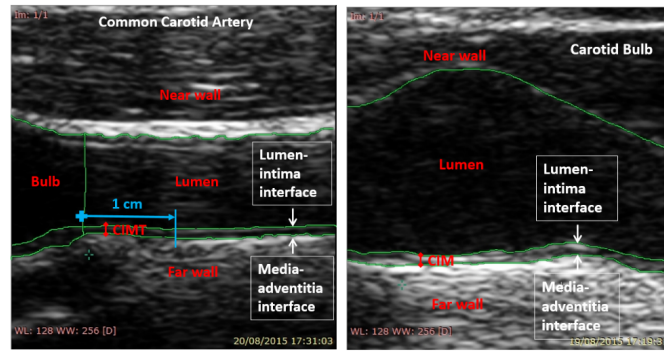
CCA and bulb ultrasounds with the delimitation of their regions.
